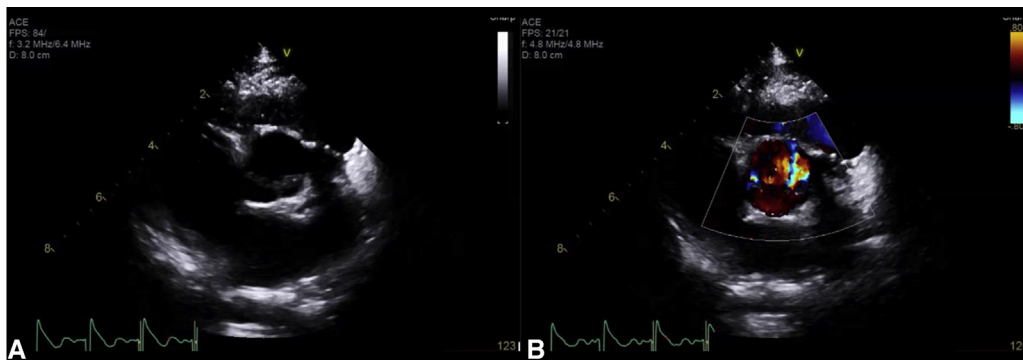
Preoperative echocardiogram. A, Short-axis view of quadricuspid truncal valve with dysplastic posterior leaflets joined side-to-side with large regurgitant orifice. B, Color Doppler with large eccentric regurgitant jet.
